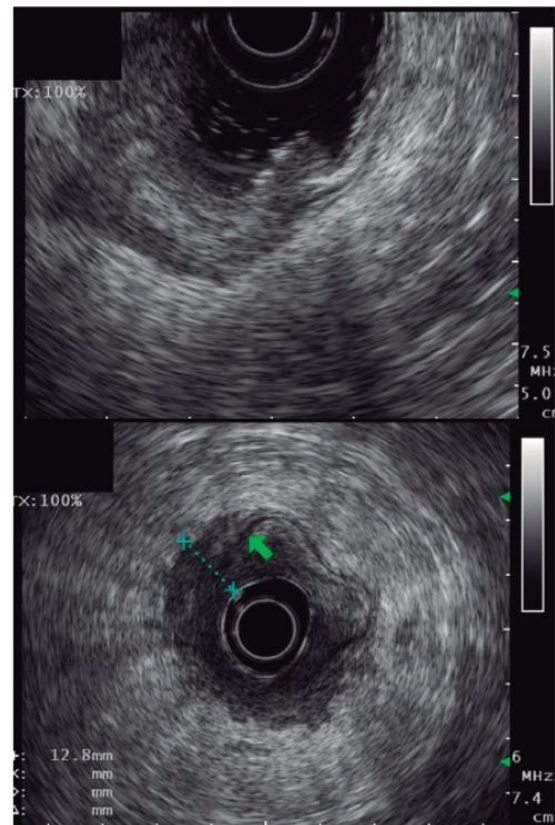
Endoscopic ultrasound evaluation of the primary tumor (T) according to TNM in rectal cancer. The tumor invades through the muscularis propria into the peri-colorectal tissue (T3).
